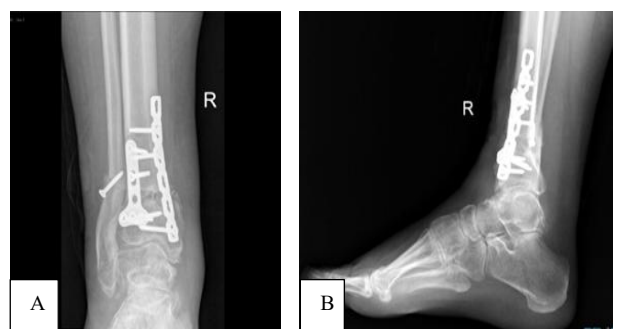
(A and B): Radiograph in 6 months follow-up.
